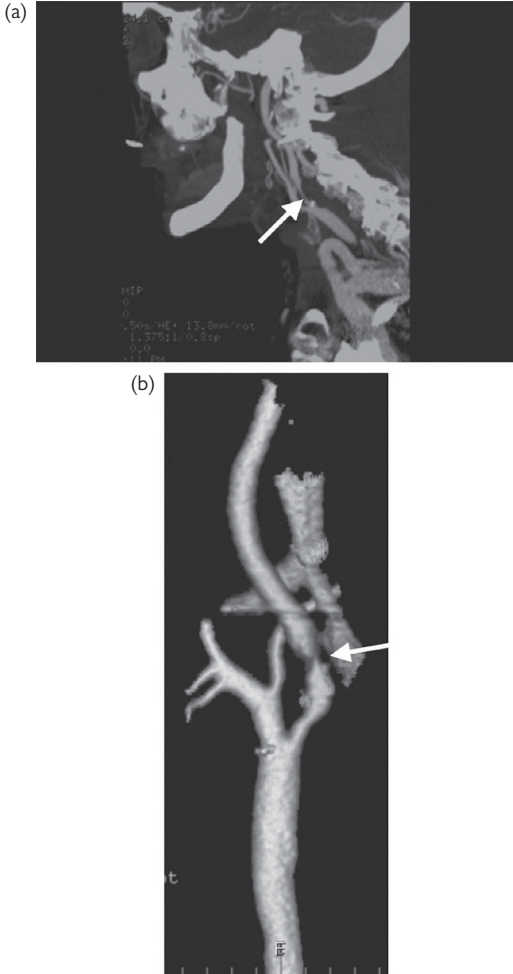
CTA imaging of carotid stenosis. (a) On the upper image there is a proximal ICA stenosis with a speck of calcium visible in the plaque as high signal. (b) The lower image shows a reconstructed three-dimensional image from another patient with carotid stenosis. In both cases the stenosis is arrowed. © Hugh Markus.
